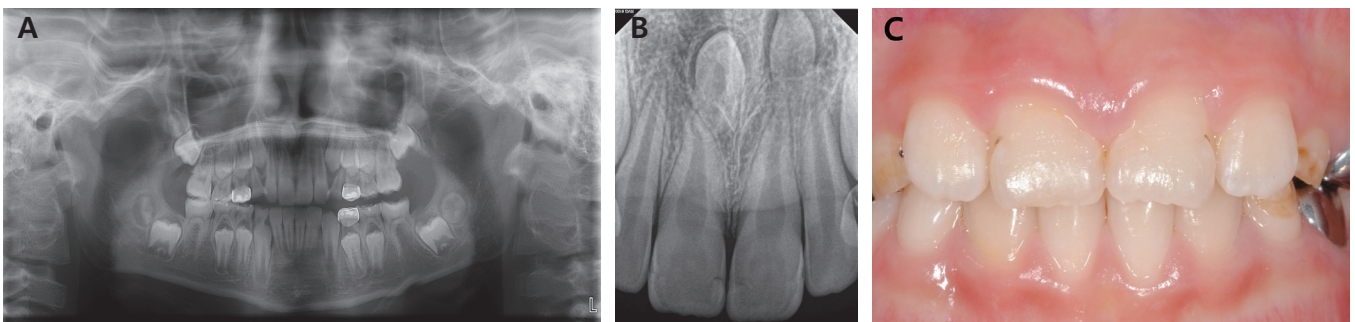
Radiographs and a clinical photograph of patient 3. (A) Initial panoramic view shows divergent and thin roots of permanent first molars. (B) Intraoral radiograph of central incisors. (C) Clinical photograph of the maxillary central incisors shows wedge-shaped notches in the middle of the crown.
